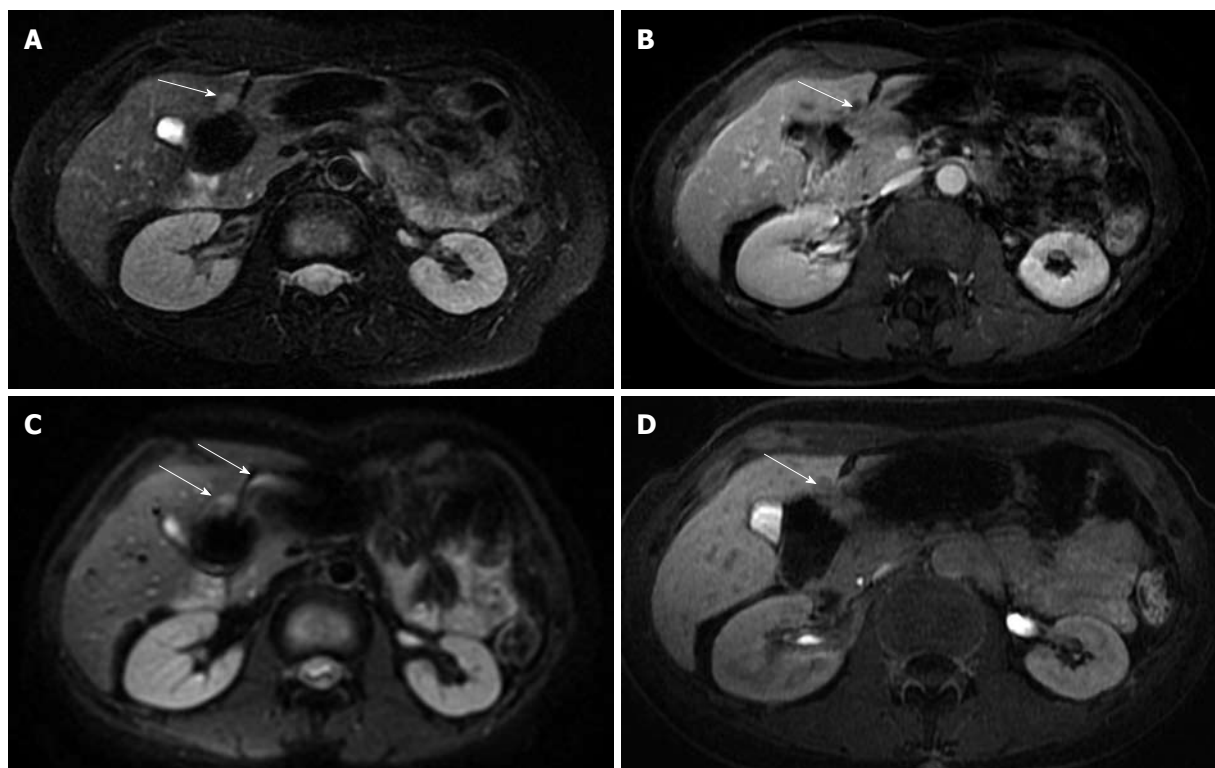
Metastasis in the IV segment. A: A metastatic lesion in colon carcinoma is depicted in the most caudal area of the IV liver segment, it was well depicted in the fat-suppressed fast spin-echo T2-weighted sequence (arrow); B: In the gadolinium-enhanced acquisition (arrow); C: The lesion is poorly represented in the diffusion-weighted imaging, covered by magnetic susceptibility artifacts due to the adjacent intestinal loop (arrows); D: Delayed imaging after gadolinium-ethoxybenzyl-diethylenetriamine pentaacetic acid confirmed the metastatic lesion (arrow).
